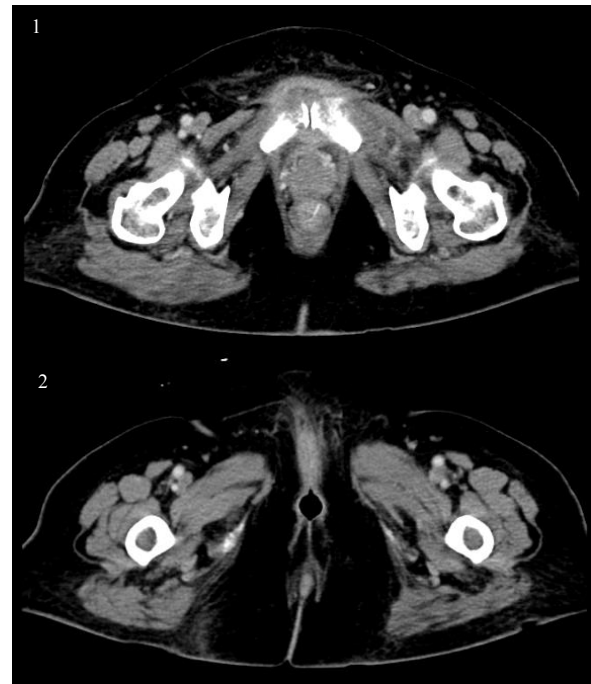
Contrast CT scan revealed ill-defined rim enhancing collection at the insertion of rectus abdominis and surrounding pubic symphysis measured 1.2x1.7x2.5cm (APxWxCC)
